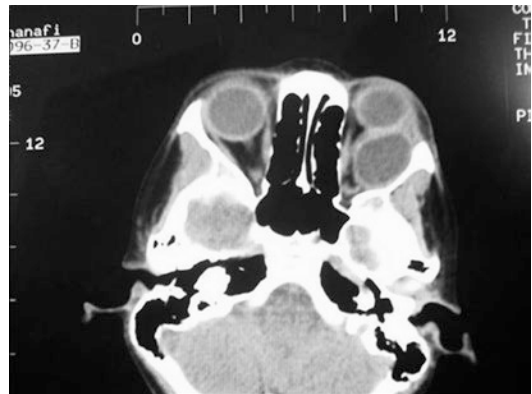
CT scan documenting serious ocular disorganization without any other serious cranial abnormality
